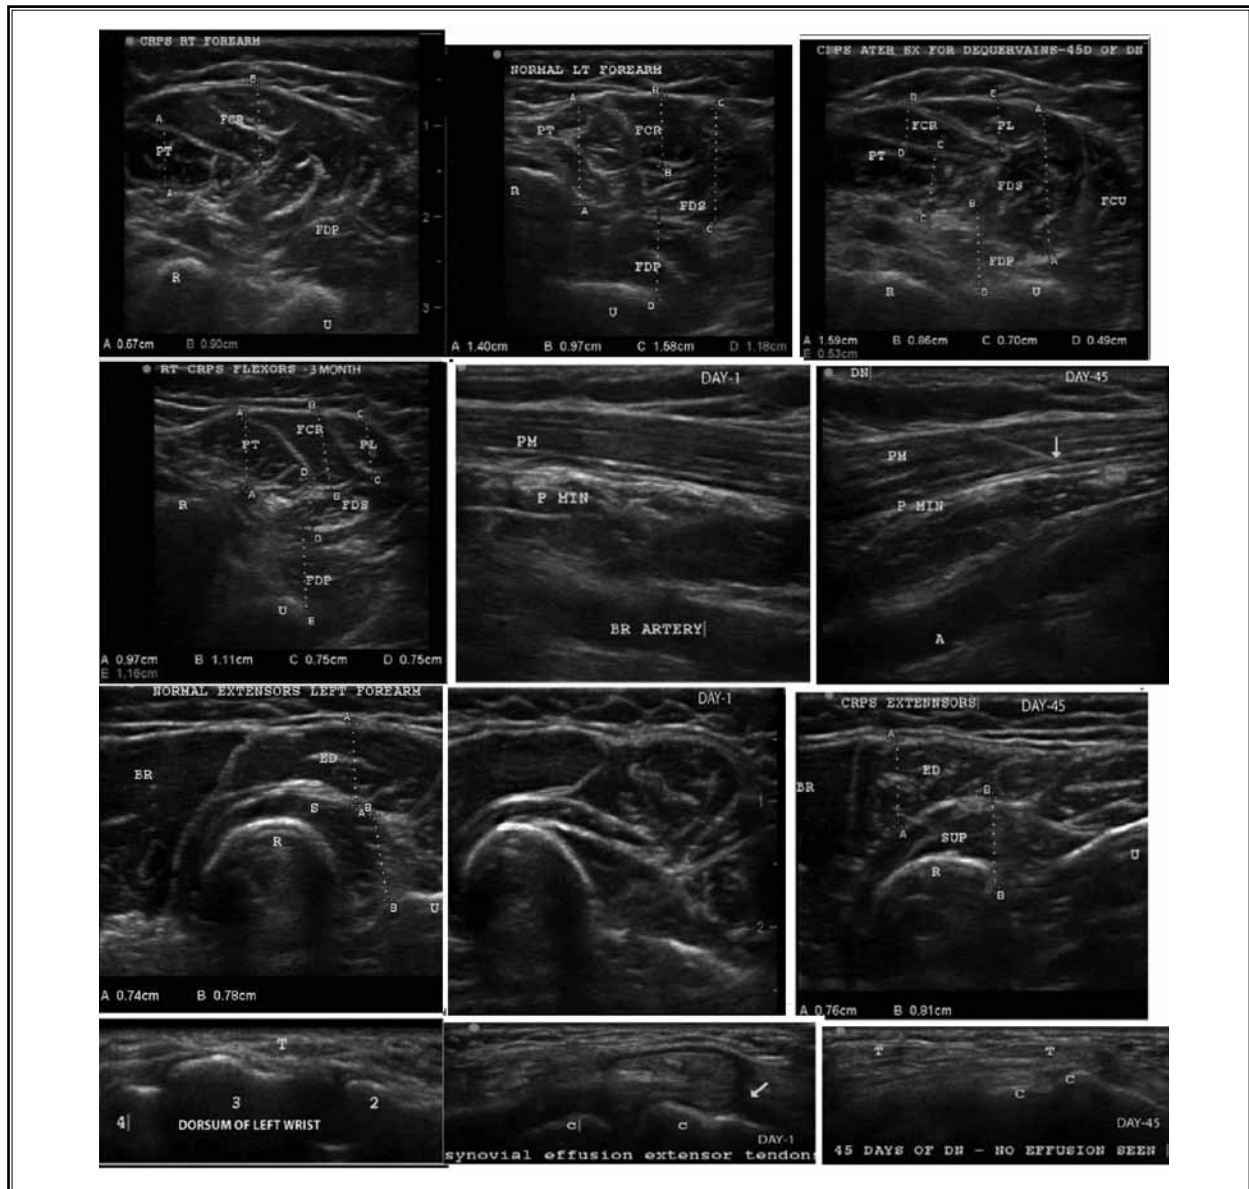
Muscle ultrasonography shows the wasted muscles in the right extremity
